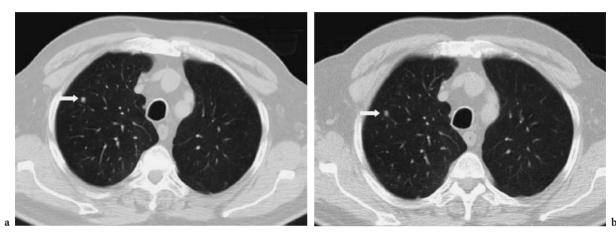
Lung nodule (*arrow*) assessed with CT performed at 120 kV, 130 mA (a) and at 120 kV, 15 mA per rotation (b). There is increased noise in the CT image performed with lower parameters but the nodule detection (*arrows*) remains unchanged
